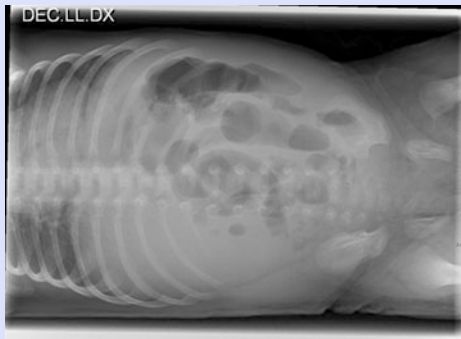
Suspected intestinal occlusion in a female newborn. The right lateral decubitus abdominal x-ray shows some small bowel air-fluid levels in central abdominal quadrant
